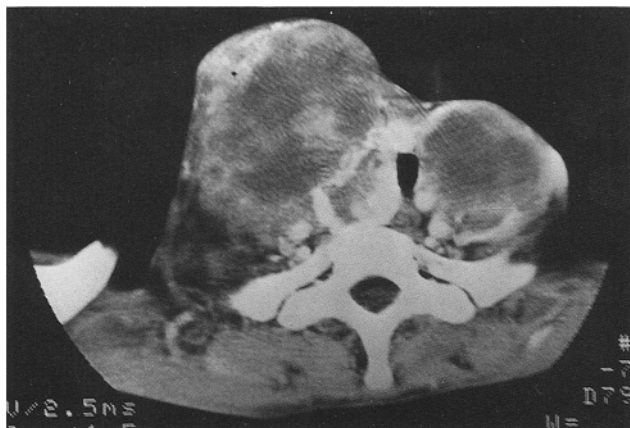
Computed tomography showed a calcified mass extending to the neck
